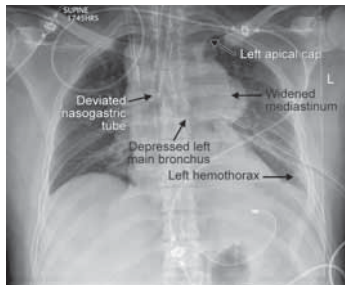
Chest roentgenogram in a polytrauma patient with left hemothorax (left intercostal tube in situ) with widened mediastinum suggestive of traumatic aortic dissection
